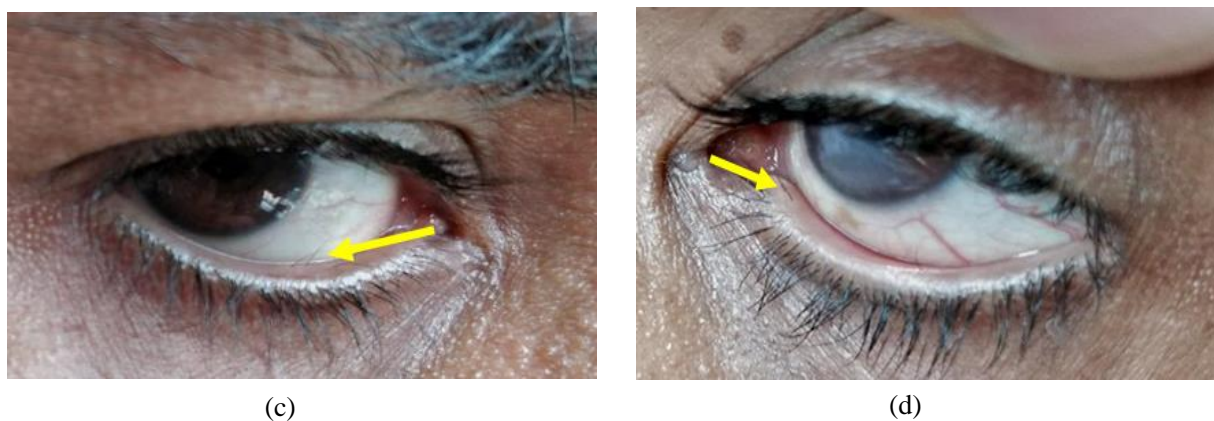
Clinical presentation of a 32-year-old Bangladeshi male with lymphedema distichiasis, (a) the lymphedema of the legs and feet, (b) Lymphoscintigraphy image of both legs, (c, d) Distichiasis in lower eye lids of the left and right eye respectively.
